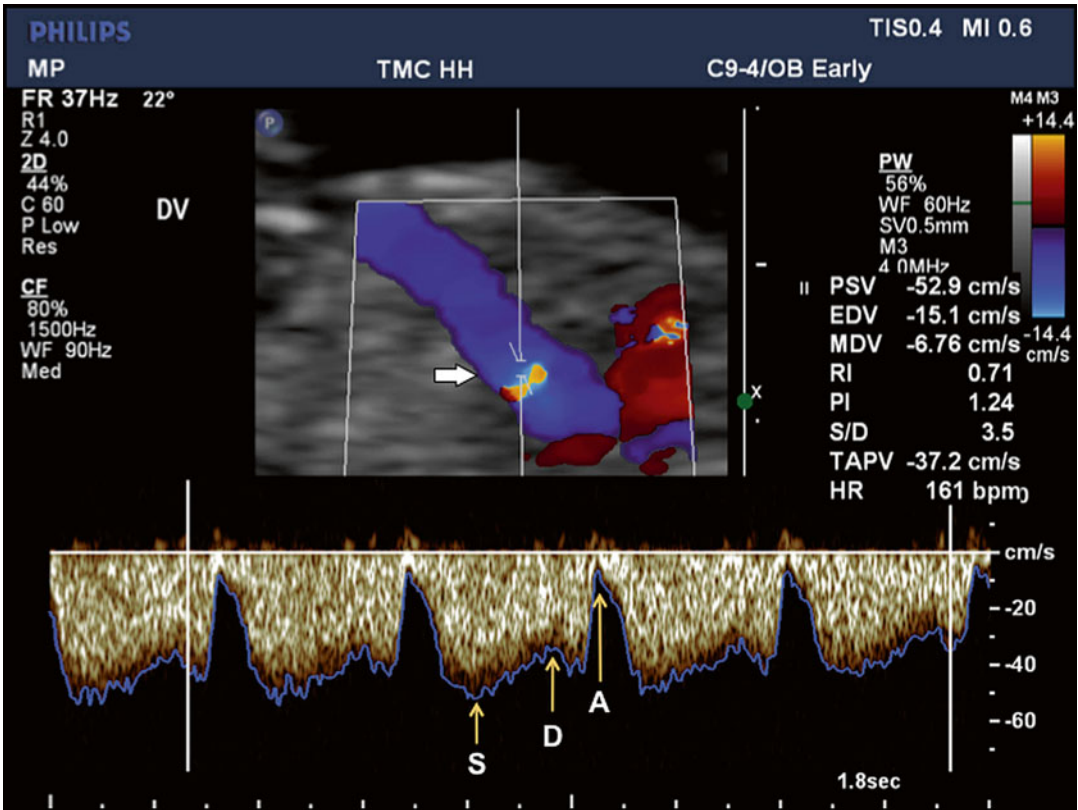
Doppler ultrasound imaging of ductus venosus flow in the sagittal plane at 12 weeks' gestation is depicted in color Doppler and spectral Doppler modes. The *upper panel* shows color Doppler flow pattern with aliasing related to high velocity, which guides the placement of the Doppler sample volume (*horizontal arrow*). The flow is
